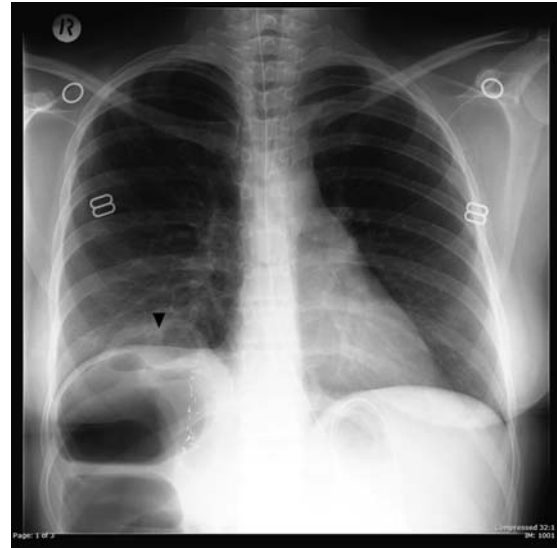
Erect chest radiograph showing a loop of bowel (arrowhead) projecting above the right hemidiaphragm. Clips are seen in the right upper quadrant consistent with previous liver surgery.
